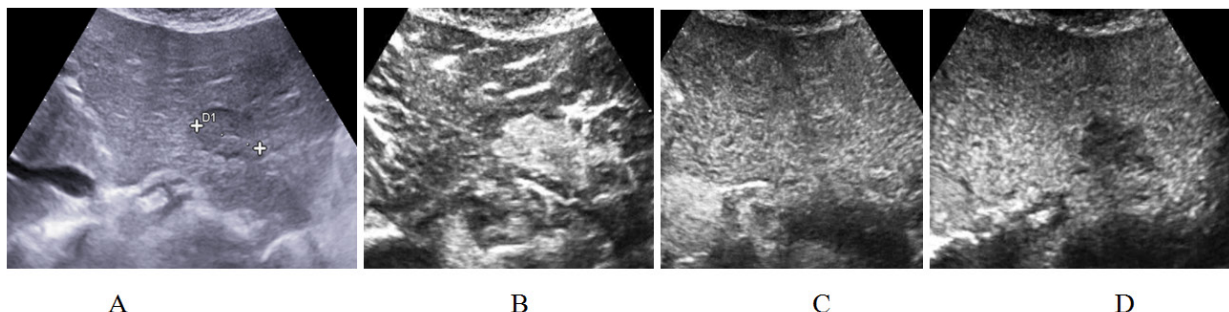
A) B-Mode ultrasound shows a homogenous iso-hypoechoic nodule with thin peripheral hypoechoic halo; B) During arterial phase the CE time of the lesion started after 17 s, with a complete and homogeneous hyperenhancement; During portal phase (C) and late phase (D), the nodule presents hypo enhancement.
